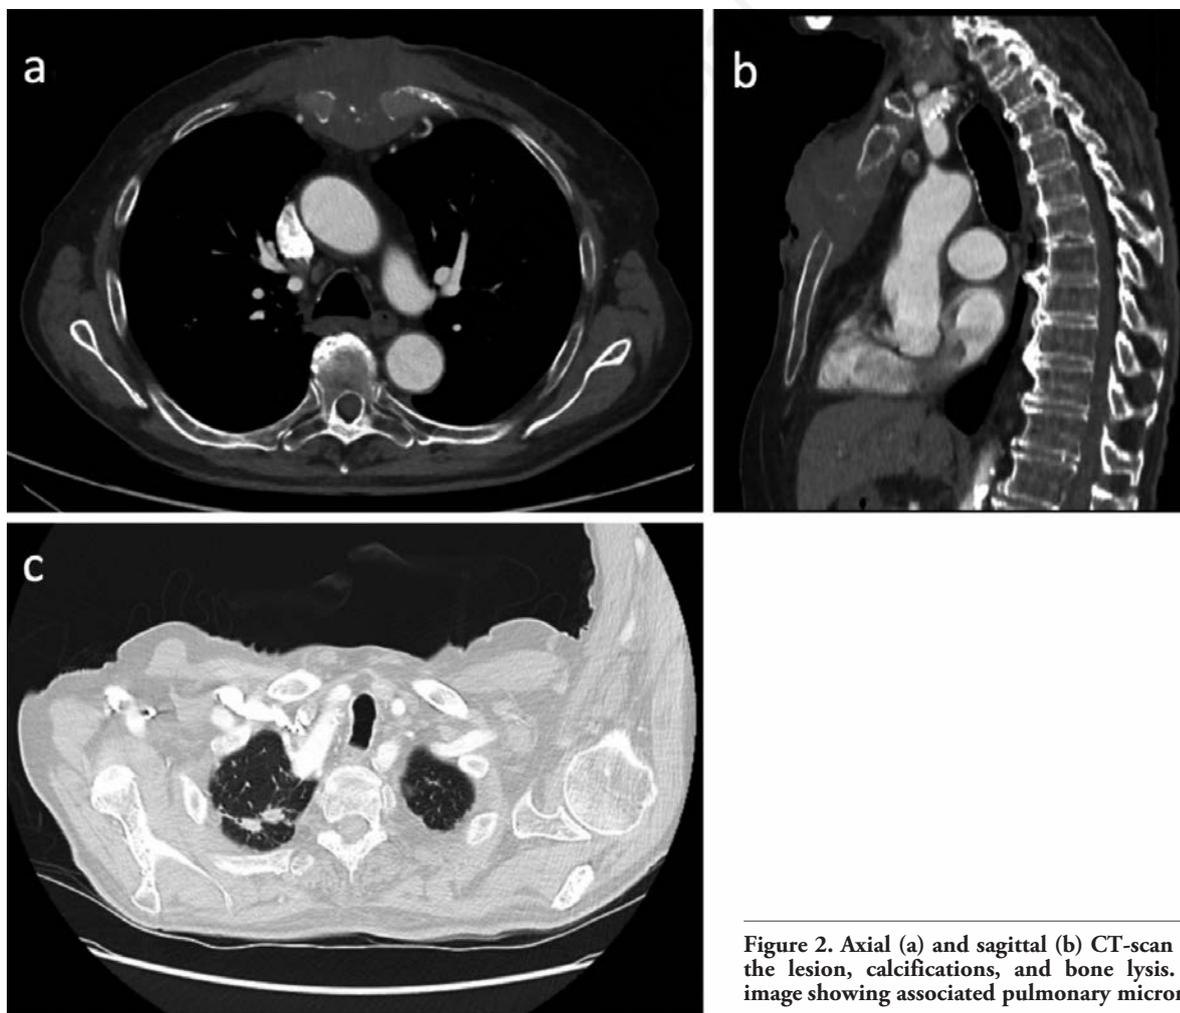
Axial (a) and sagittal (b) CT-scan images showing the lesion, calcifications, and bone lysis. Axial CT-scan image showing associated pulmonary micronodules (c).
